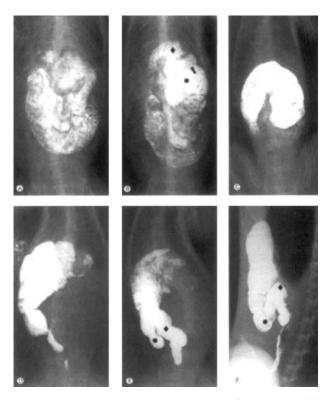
A) DV radiograph of iguana 2 made 5 h after barium administration. Residual barium can be identified in the stomach and the descending duodenum. Barium can be identified in the ileum as it enters the first compartment of the large colon. B) DV radiograph of iguana 6 made 8 h after barium administration. The first compartment of the colon (asterisk) and the transverse colon (diamond) can be identified as the barium progresses through the circular valve (arrow). C) DV radiograph of iguana 1 made 16 h after barium administration. All of the large colon and the circular and semi-circular valves can be identified. D) DV radiograph of iguana 1 made 36 h after barium administration. The first compartment of the large colon is beginning to empty. Barium can be identified in parts of the small colon. E) DV radiograph of iguana 1 made 48 h after barium administration. The caudal (asterisk) flexure and the distal descending (diamond) limb of the small colon can be identified overlying the large colon. F) Lateral radiograph of iguana 5 made 24 h after barium administration. The large colon and the proximal descending, ascending, distal descending limbs, and cranial (diamond) and caudal (asterisk) flexures of the small colon can be identified.
